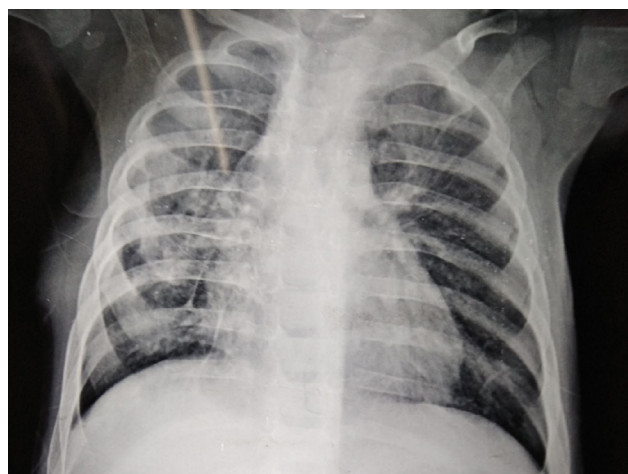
X-ray chest showing cystic lucency right upper lobe in a patient with right upper lobe congenital pulmonary airway malformation
